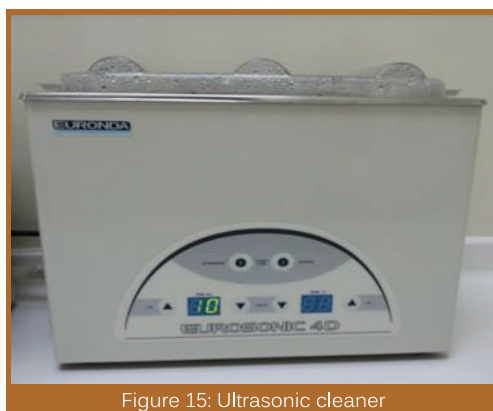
Ultrasonic cleaner
